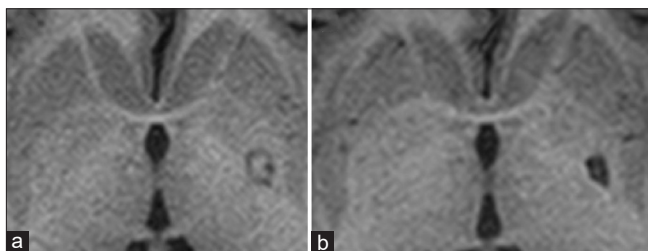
Post-operative T1-weighted MRI (a) showing coagulated lesion in the left globus pallidus internus on the day of the surgery. (b) Showing old scar on the left globus pallidus internus 3 months after left pallidotomy.
